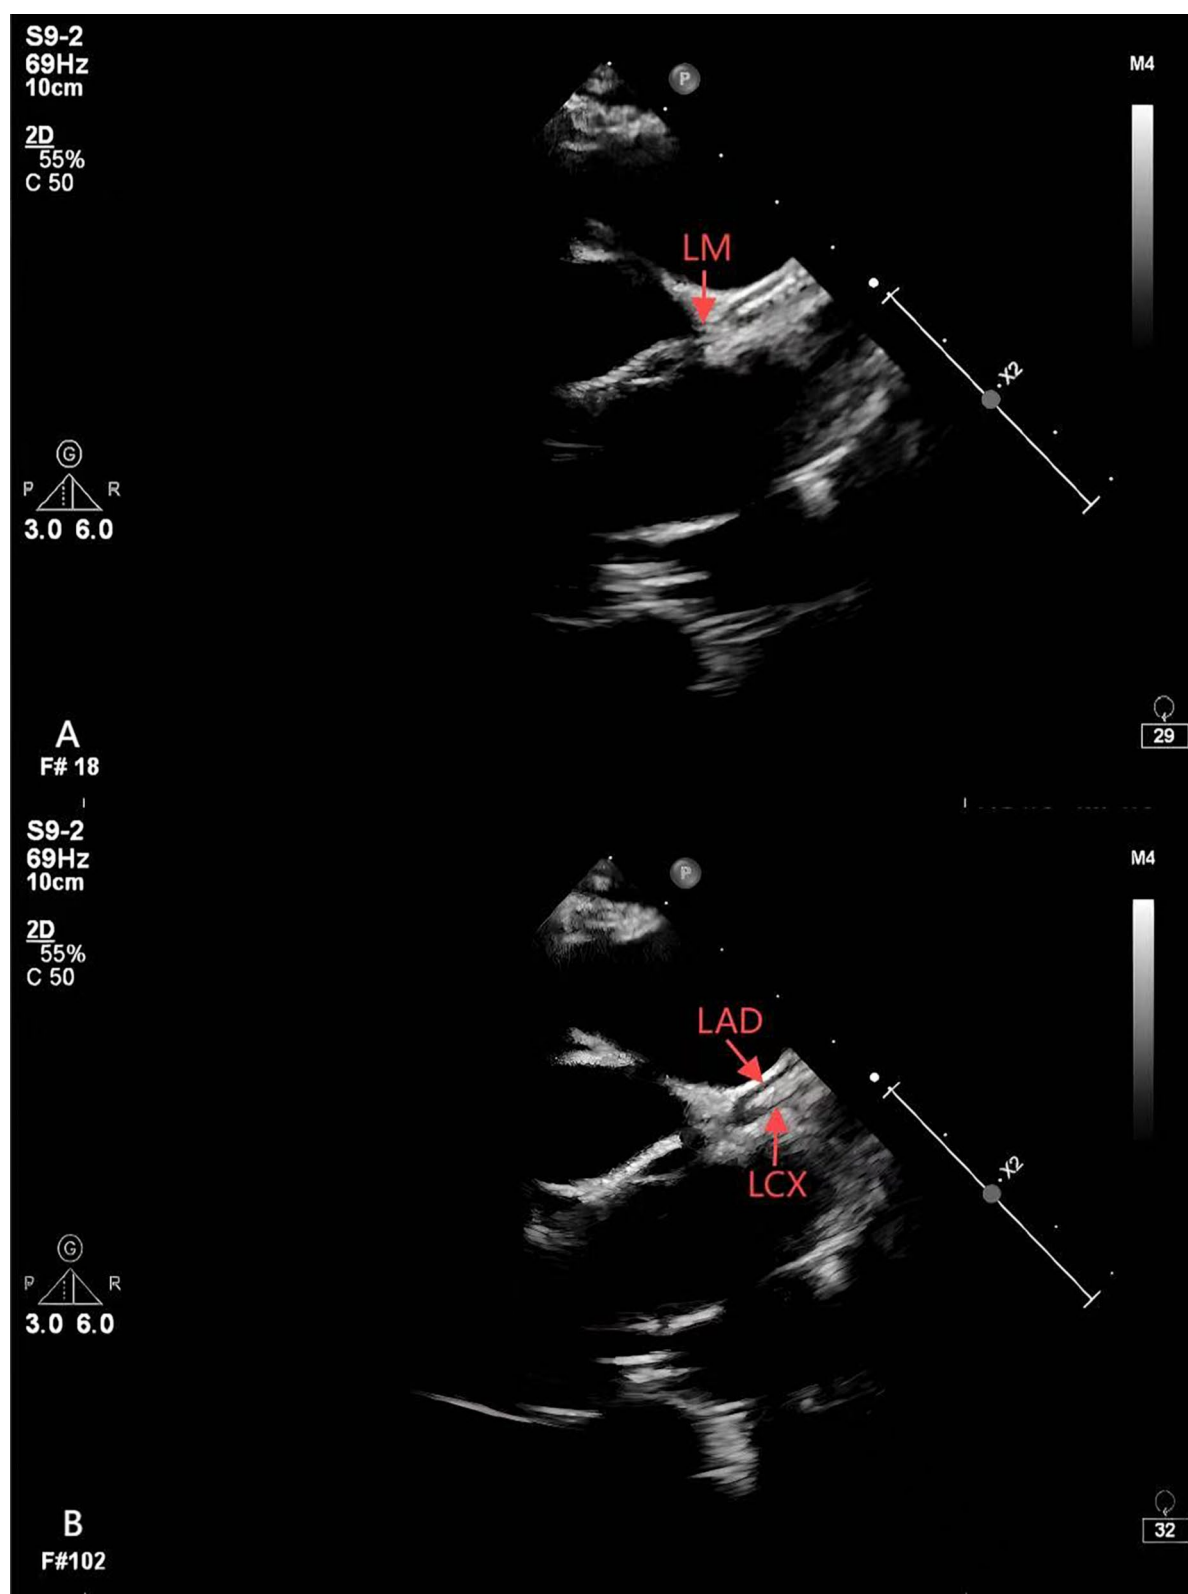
Modified view of the parasternal short axis in echocardiography: (A) The left main coronary artery exhibits stenosis and is not clearly displayed at its opening. (B) The left anterior descending branch and the left circumflex branch are distinctly visualized
